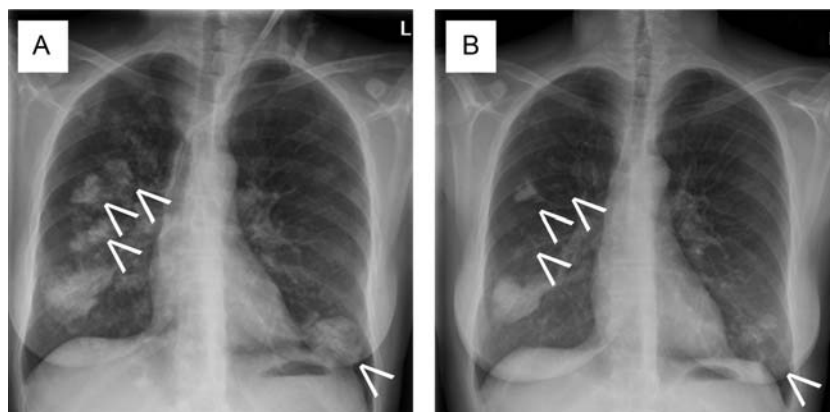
Chest X-rays. Diffuse nodular opacities can be seen in both lungs (A; arrows). One year after intensifying the dialysis regimen and optimization of the calcium–phosphate regulation, a significant reduction of the opacities can be seen (B).
